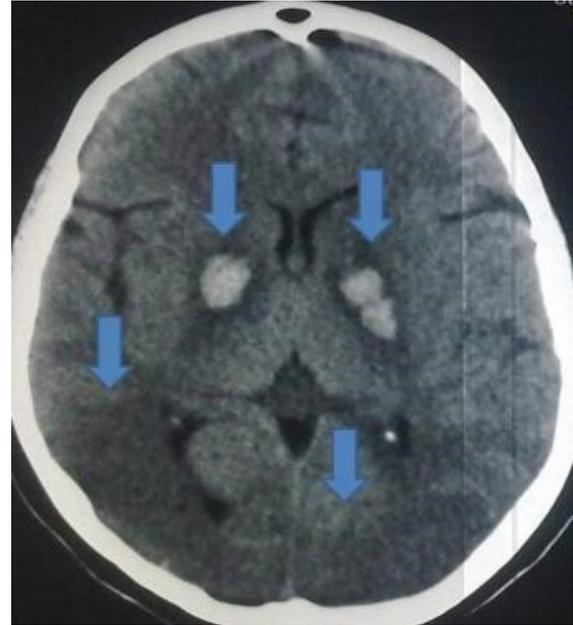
Cranial CT, day 15, enhance on symmetrical density elevation, edema around hemorrhage areas.
